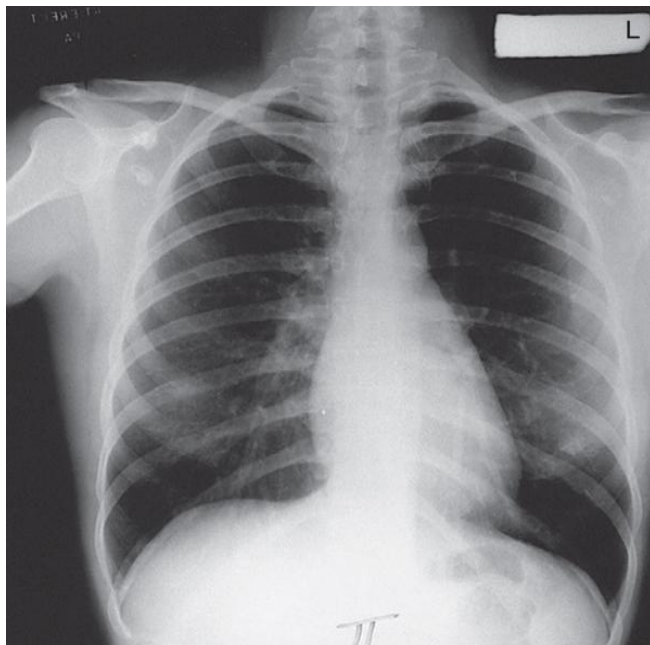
A normal chest radiograph(source: *Clark's positioning and techniques*).
